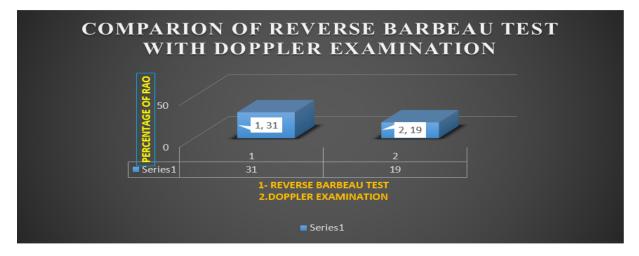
Comparison of reverse Barbeau test with Doppler examination
